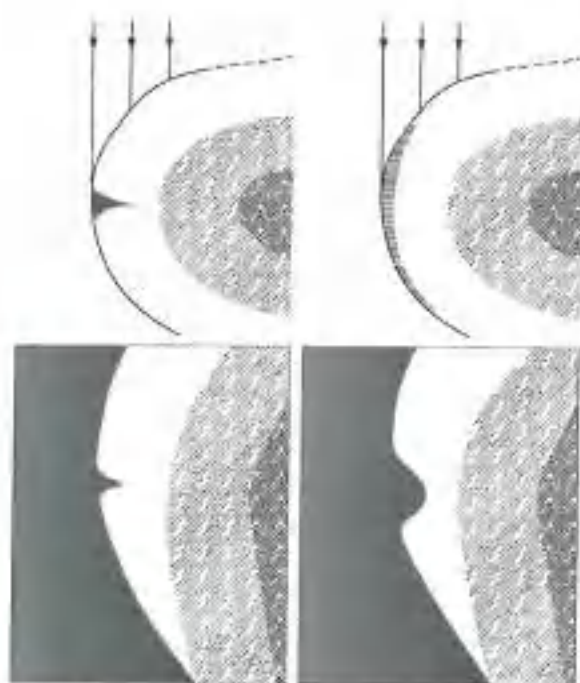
The shape and extent of a lesion influence its radiographic depiction. A superficial lesion with a great extent along a proximal surface may seem both deeper and darker than a lesion that is smaller in the direction of the X-rays but actually deeper.
